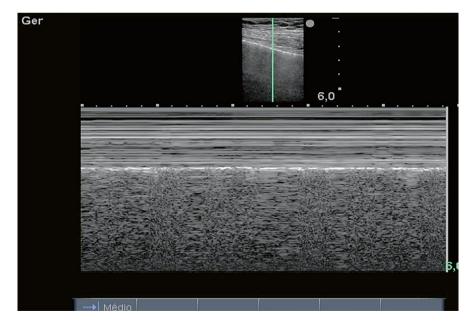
Analysis of M-mode pleural slippage on ultrasound
